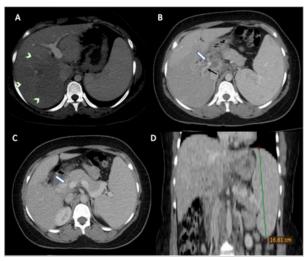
(A) Axial contrast enhanced CT demonstrates areas of relative hypoattenuation on PV phase (white arrow heads). (B) Right branch of PV is significantly attenuated. MPV is also significantly attenuated and replaced by multiple collaterals at porta & in pericholedochal region (black arrow). (B & C) Pericholedochal collaterals are causing significant luminal narrowing of the CBD in its supraduodenal & intrapancreatic segments (white arrow) suggestive of portal biliopathy. (D) Coronal contrast enhanced CT demonstrates splenomegaly
